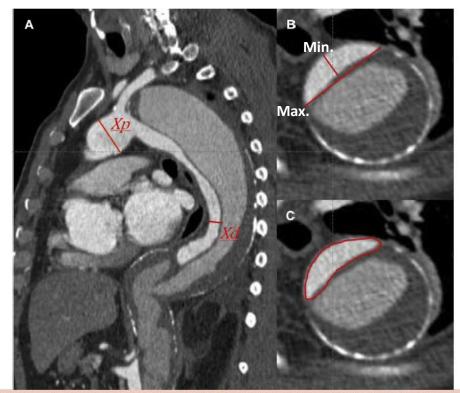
A, Saggital computed tomography (CT) view before thoracic endovascular aortic repair (TEVAR) shows the size of presumed proximal landing zone (*Xp*) and the size of the presumed distal landing zone (*Xd*). B, Maximal and minimal diameter and mean diameter of Xd. C, Area and circumference of Xd.
